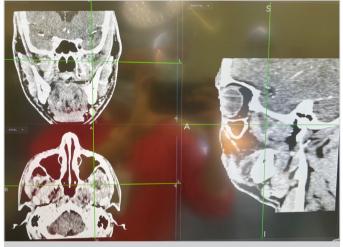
Intraoperative CT-guidance imaging: The image-guided Frazier tip suction and probe are shown in the infratemporal fossa abscess under live image localization using intraoperative CT-guided imaging in coronal, axial, and sagittal views
